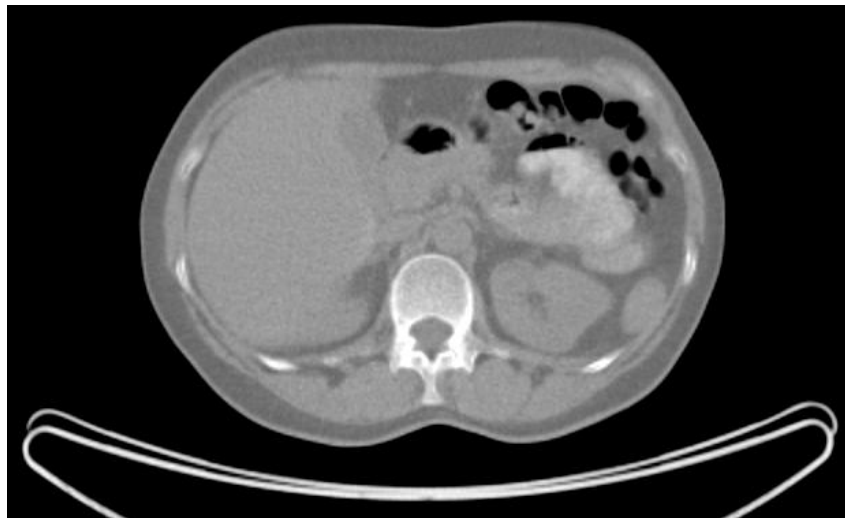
Example of a CT transaxial slice of the abdomen acquired with a Siemens 64-slice CT. A good contrast can be observed between air, adipose tissue (fat), soft tissue and bone.
